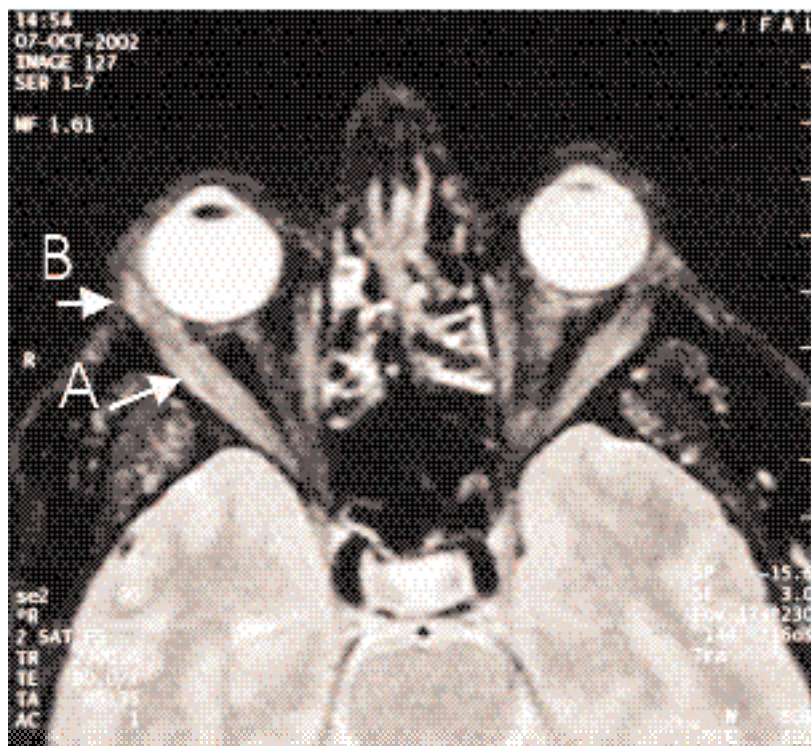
Orbital MRI (T1 sequence) showing enlargement of the muscle bellies (arrow A), as well of the tendons of the orbital muscles (arrow B) in a patient who developed bilateral ocular myositis as a late complication of dermatomyositis.
